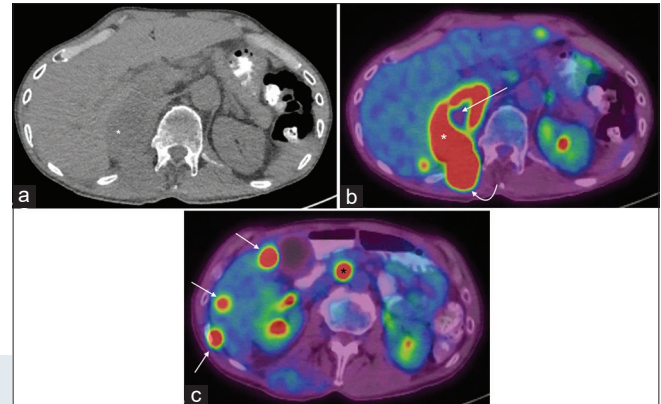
A 65-year-old male with metastatic squamous cell carcinoma. (a) Axial non-contrast-enhanced computed tomography (CT) demonstrates a significant increase in the right adrenal soft tissue lesion (white asterisk). (b) Axial fusion positron emission tomography (PET)/CT demonstrates a hypermetabolic right adrenal lesion (white asterisks) with a necrotic center (straight white arrow). There is an additional hypermetabolic soft tissue nodule in the right paraspinal muscles (curved white arrow), which is contiguous with the hypermetabolic right adrenal lesion. (c) Axial fusion PET/CT demonstrates numerous hypermetabolic hepatic metastases (white arrows). There is an additional enlarged, hypermetabolic para-aortic lymph node (black asterisk)
